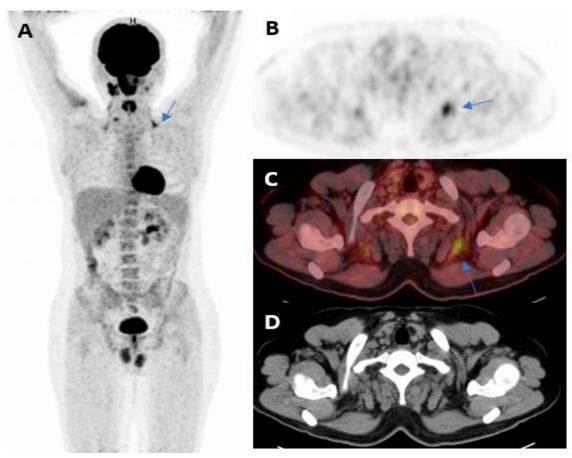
A 30-year-old male diagnosed with Hodgkin lymphoma, mixed cellularity subtype, (A) maximum intensity projection image shows mild brown fat uptake in the supraclavicular region only, (B) transaxial PET images, (C) transaxial PET/CT fused images, and (D) the corresponding CT reveal that 18F-FDG uptake corresponds to fatty tissue (HU of -90).
